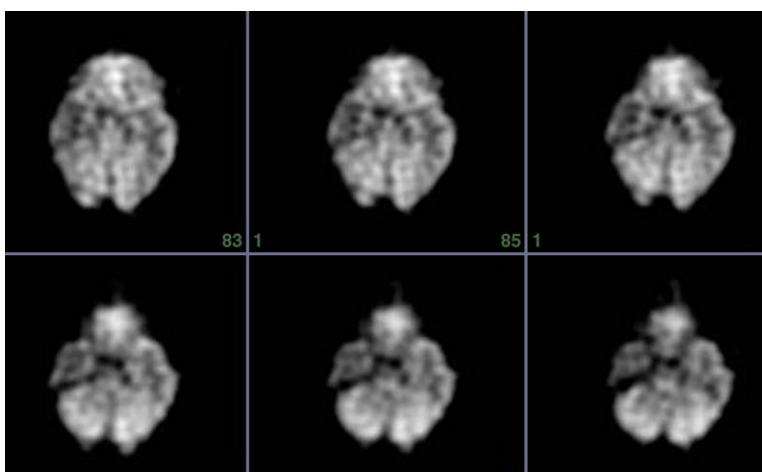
Interictal FDG-PET scan of a patient with temporal lobe seizures refractory to medical treatment. The scan demonstrates moderate hypometabolism in the right temporal lobe consistent with a seizure focus.
